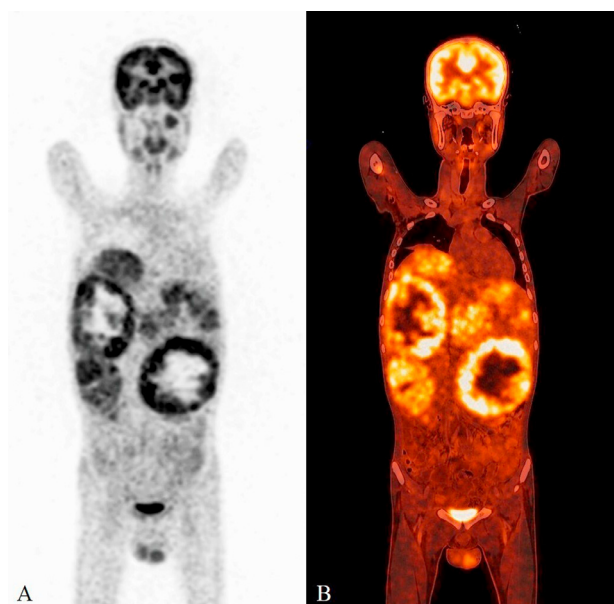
Hepatic epithelioid hemangioendothelioma: PET-CT coronal showing pathologic 18F-FDG uptake in the multiple hepatic lesions with characteristic peripheral uptake in the larger lesions giving a ring of fire appearance in fused image (B).
